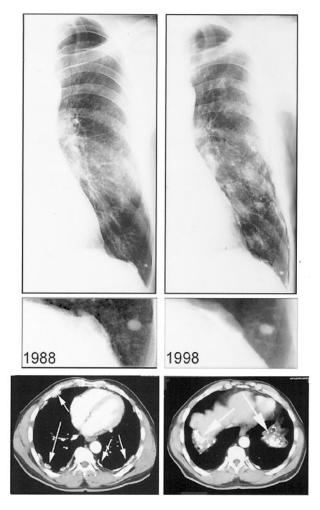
Pleural and diaphragmatic plaques. Changes in the size and shape of pleural plaques, and in their calcification occur very slowly. Note the "mushroom cap" shape of the diaphragmatic plaque. The CT scan (*bottom panels*, different patient) may show extensive pleural changes that are not otherwise evident. There are multiple sites of pleural thickening and calcification in the mid-lung region (*bottom, left*) and on the diaphragm (*bottom, right*).
